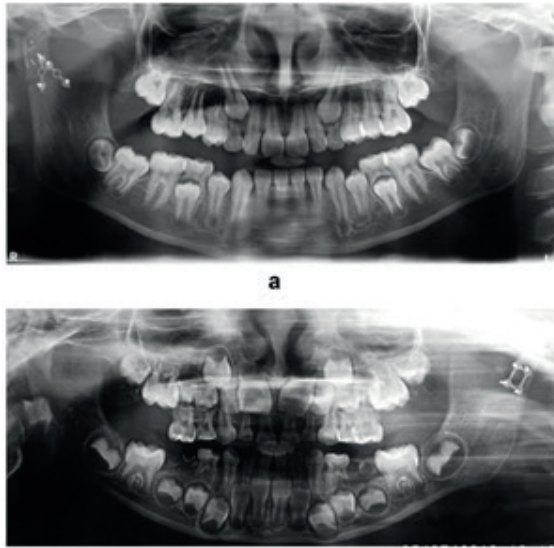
Use of Panoramic Radiography in Pediatric Mandibular Fractures(Vesnaver, 2020)
